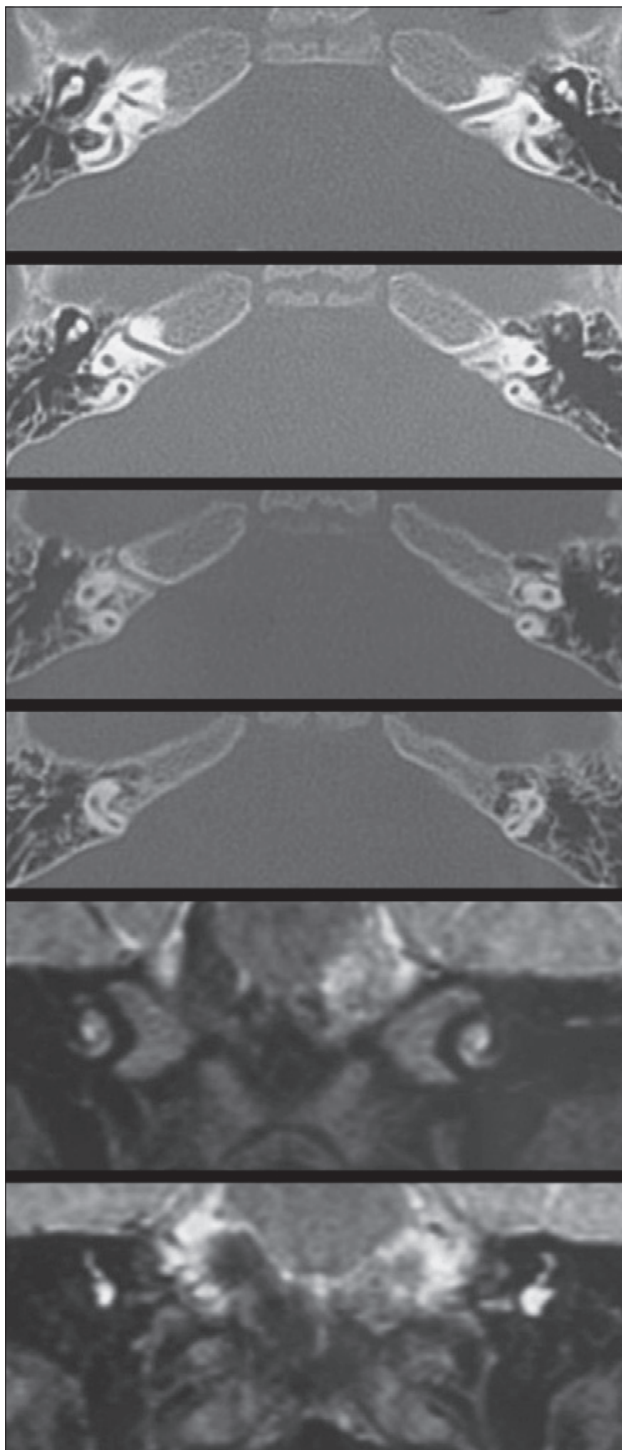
CT and MRI of narrow internal auditory meatus and 7th, 8th cranial nerves.
